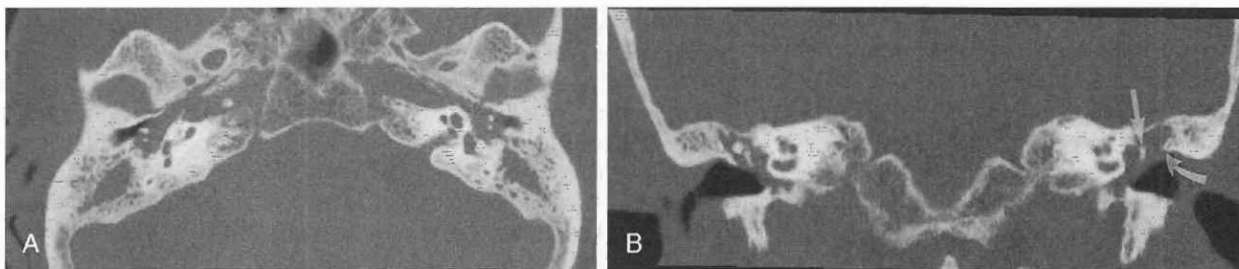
Bilateral chronic otitis media and cholesteatoma. Isotropic multislice helical CT was performed with 0.5-mm slice width. A, Axial image shows opacification of both middle ear cavities, mastoid antrum, and mastoid air cells as a result of chronic otitis. B, Coronal reformat provides excellent spatial resolution and depicts the cholesteatoma with erosion of the ossicles (*straight arrow*) and scutum (*curved arrow*).
